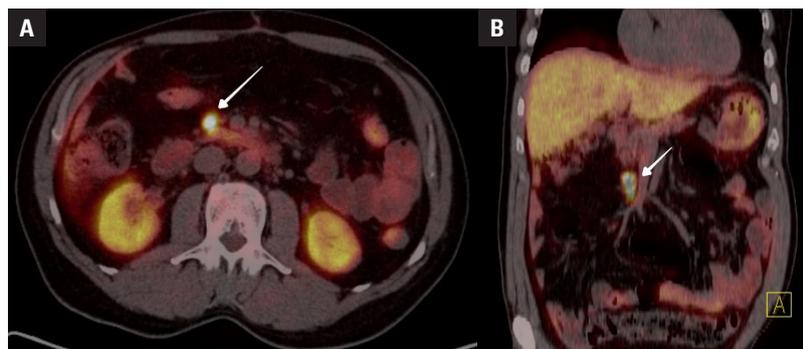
^{68}Ga Ga-DOTATATE PET/CT showing abnormal uptake near the pancreatic head and duodenal wall
